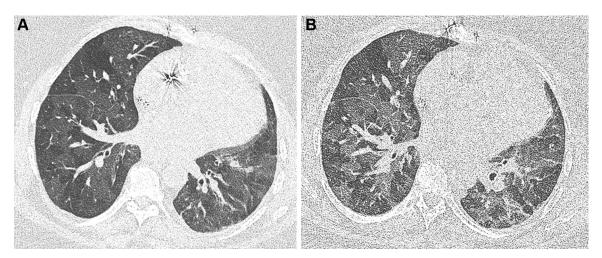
A, Inspiratory and (B) expiratory HR CT images in a 69-y-old woman with known pulmonary hypertension, showing relatively static mosaic attenuation on expiration. See Figure 24 legend for expansion of abbreviation.
